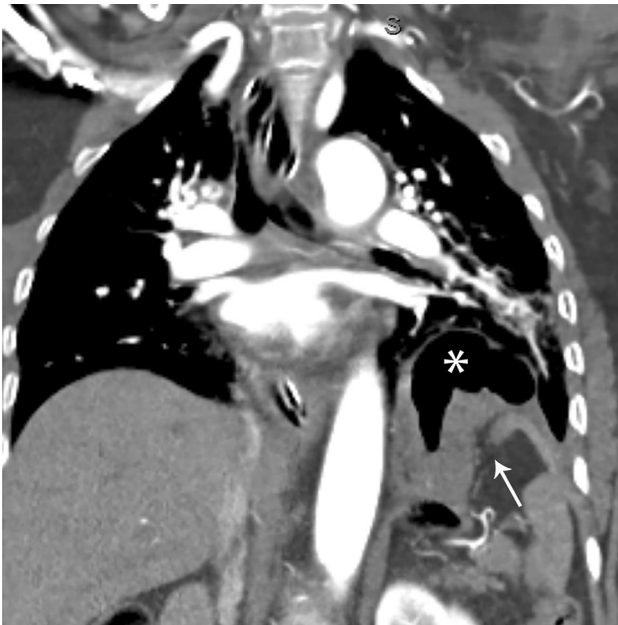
Following severe blunt trauma to the chest and abdomen, CT identified herniation of the stomach (asterisk) through a tear in the diaphragm. The diaphragm is thickened, with a segmental defect and a “dangling diaphragm sign (arrow)”
